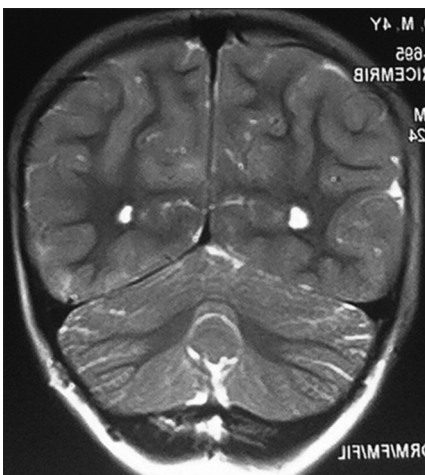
MRI T2 weighted image showing areas of hyper intensity involving white matter
